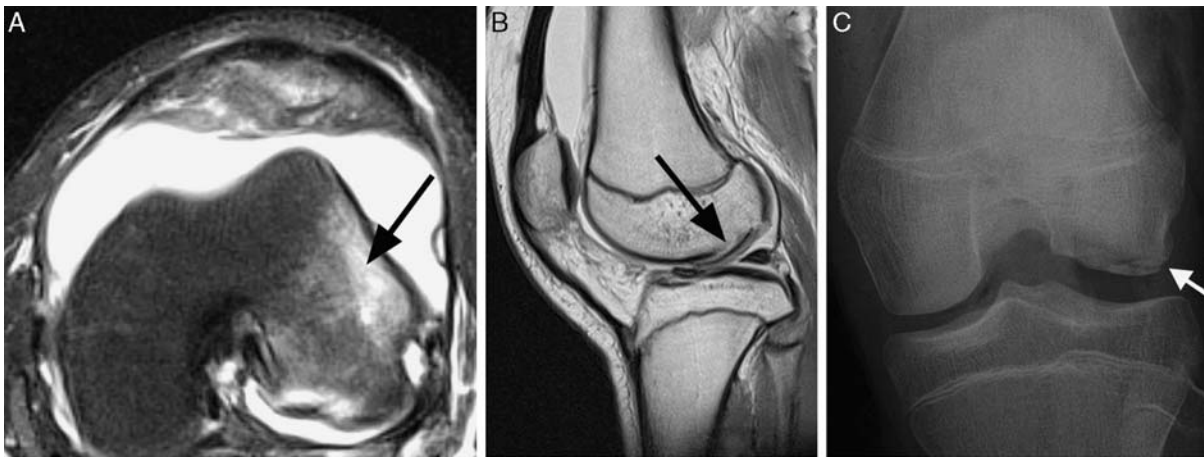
Case example of a 13-year-old female who suffered a traumatic patellofemoral dislocation with a large osteochondral fragment involving two third of the weight-bearing surface of her lateral femoral condyle. Her initial x-rays and magnetic resonance imaging show the typical lateral bone bruise (arrow, A) and the clearly displaced fragment (black arrow, B). After mini-open refixation of the fragment with double-pitched bioabsorbable screws (Arthrex, Naples, FL), the fragment was well aligned (white arrow, C). The patient-reported clinical outcomes measures (IKDC, WOMAC, Lysholm) showed a progression toward a normal knee function over 10 months postoperatively (D). Pre-op indicates preoperatively.
